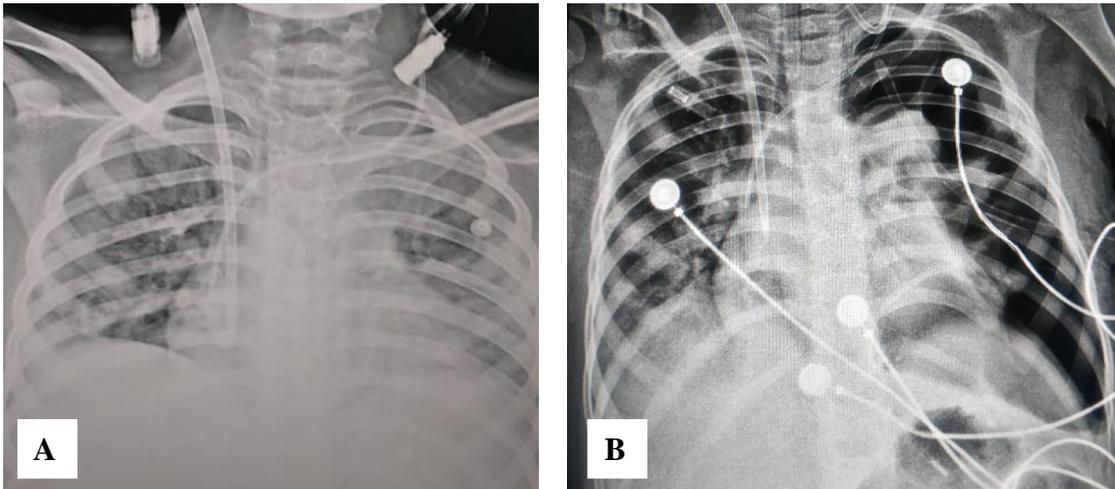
Chest X-ray of an SLE patient with COVID-19 showing bilateral consolidation (A). the patient developed spontaneous pneumothorax later on (B)
